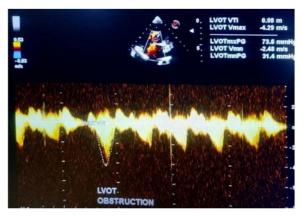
CW Doppler analysis of LVOT shows severe obstruction with a peak/ mean gradient across LVOT being 73.6/ 31.4 mmHg In the 5CH view, a turbulent mosaic pattern is delineated in the LVOT, signifying a severe LVOT obstruction (Figure 7), with a peak/mean gradient of 73.6/31.4 mmHg (Figure 8). The marked thickness of anterolateral and posterolateral LV was also visualized.
